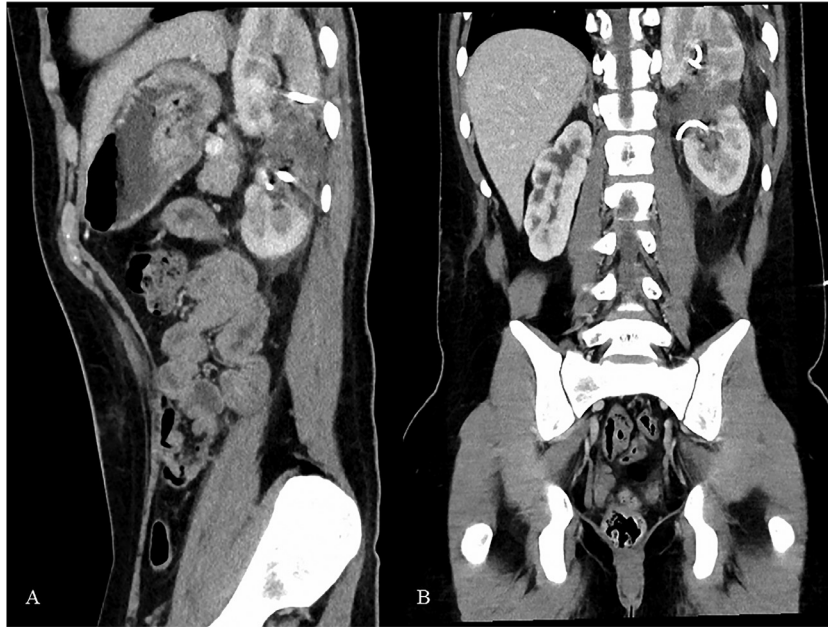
Sagittal (A) and coronal (B) CT images demonstrate a central hematoma separating the upper and lower moieties of the left kidney. Linear hyperdensities in the upper and lower moieties, best seen on image B, are upper and lower nephrostomy tubes present at the time of imaging.
